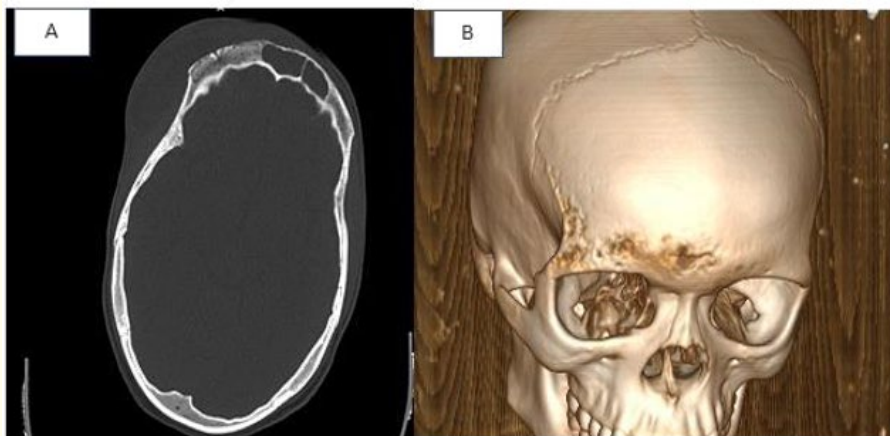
Axial CT bone windows (A), 3D Reconstruction 3D (B) Demonstrate extensive osteomyelitis of the right frontal bone.
